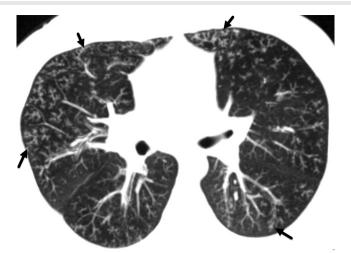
A 32-year-old female patient with a diagnosis of systemic lupus erythematosus. Chest CT image shows severe centrilobular lung nodules with tree-in-bud appearance in both lungs, compatible with bronchiolitis (arrows).
